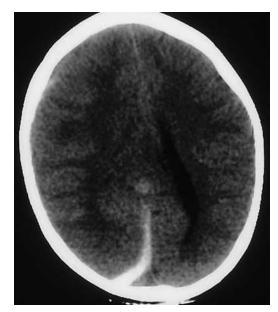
Focal occipital and interhemispheric subdural blood are seen in this toddler who "collapsed at home after a fall from her crib." Note the effacement of the right lateral ventricle and slight anterior midline shift due to cerebral edema. Her bone scan is shown in Fig. 6-41, *B* and her abdominal CT in Fig. 6-58.
